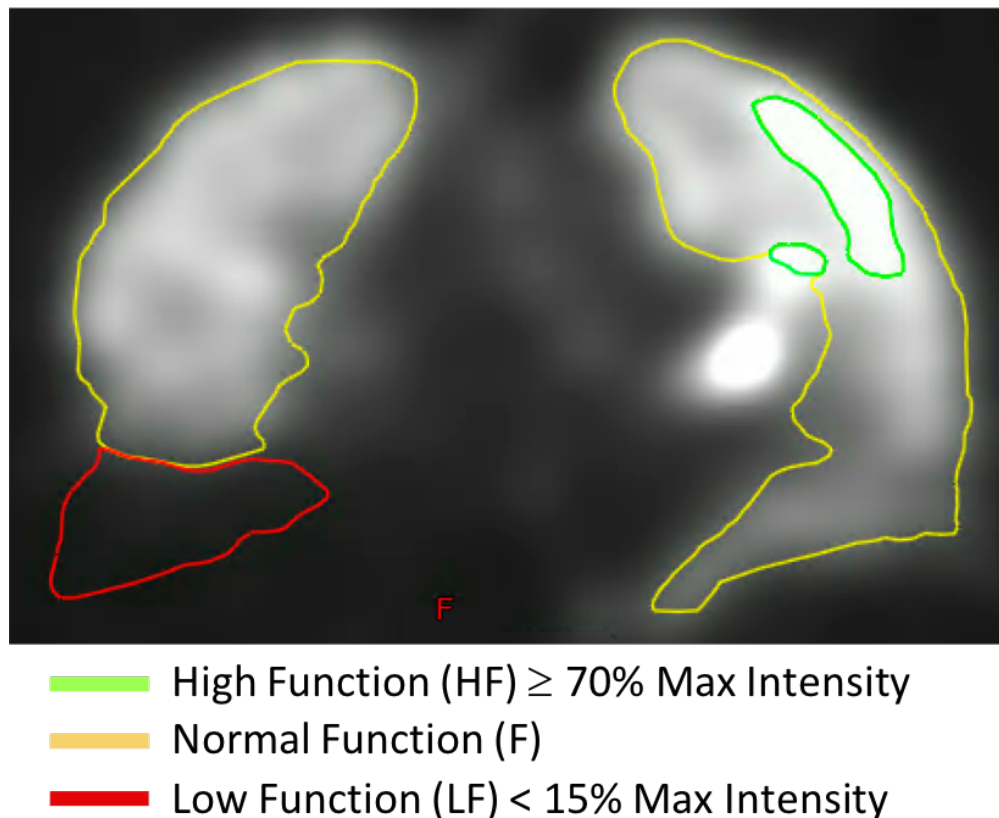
Example perfusion SPECT image demonstrating the functional categorizations for example patient UM025.
